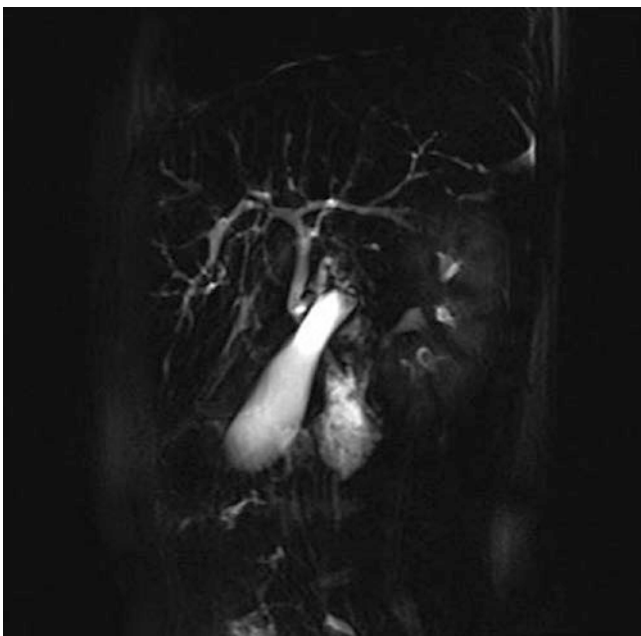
Autoimmune sclerosing cholangitis: Magnetic resonance imaging showing diffuse cholangiopathy with ductal changes in both liver lobes
